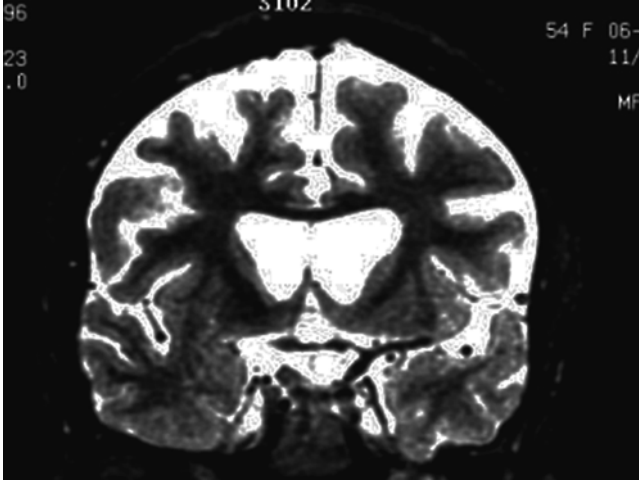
This MRI is from 50 year old female patient who for several years had been noted to be nervous and had many restless movements. Her family felt that recently she was not thinking as clearly and had been undergoing a personality change (From Jacobson and Marcus [17])
